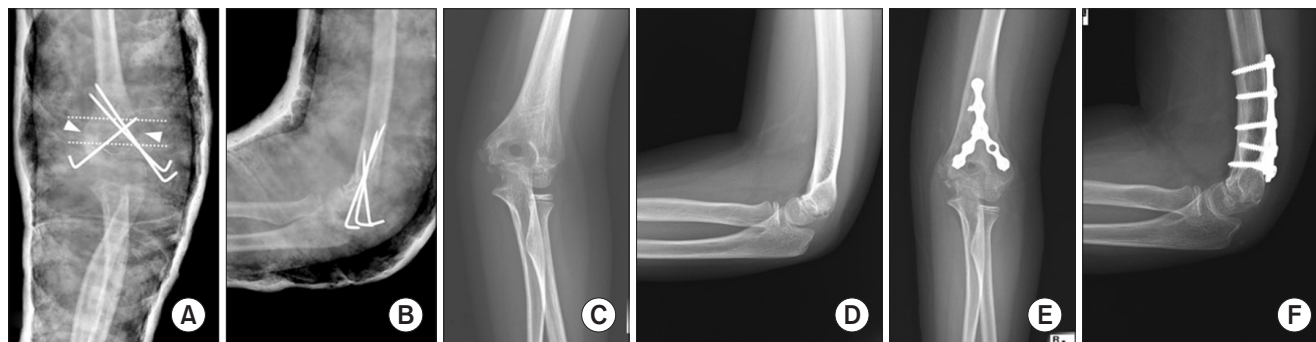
(A, B) A Gartland III supracondylar fracture in which both proximal parts of the distal fragments (white arrowheads) are located in zone 2 in an 8-year-old boy was stabilized with two percutaneous 0.062-inch Kirschner (K)-wires laterally and one K-wire medially. (C, D) Anteroposterior radiographs at 18 months postoperatively, showing 14° valgus deformity compared to the contralateral arm. (E, F) Elbow deformity was corrected with a translation step-cut osteotomy using a Y plate and screws.
